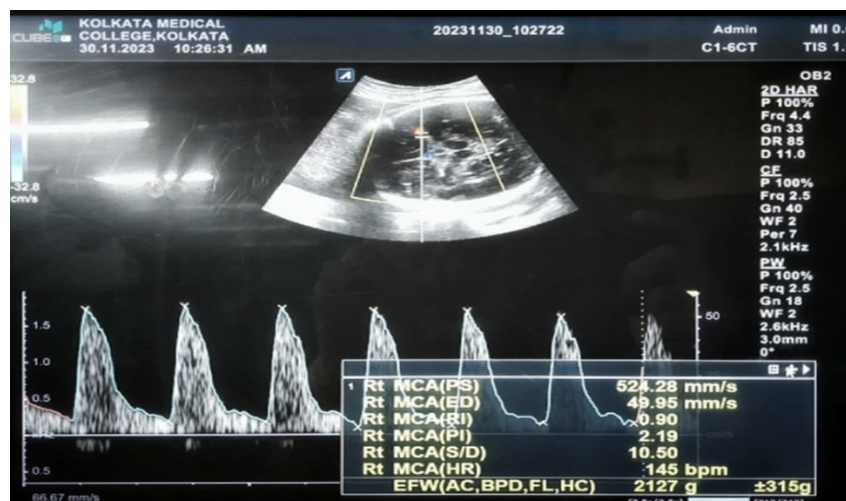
MEASUREMENT OF MIDDLE CEREBRAL ARTERY DOPPLER INDICES
